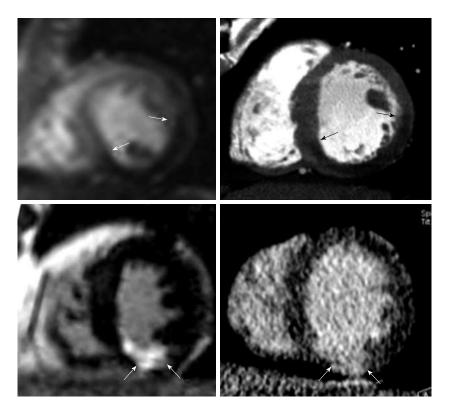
Head-to-head comparison between first pass perfusion MR (top left) and first pass multidetector computed tomography (MDCT) imaging (top right) in a 42-year-old man with acute reperfused infarct. Ischemic myocardium (arrows) appears as a hypoenhanced region with comparable extent on both imaging modalities. Bottom: Head-to-head comparison of DE-MR (bottom left) and DE-MDCT imaging (bottom right) shows a bright region comparable in size to enhanced inferior infarct (arrows). Note that the enhanced infarct on DE-imaging is substantially smaller than ischemic myocardium^[38].
